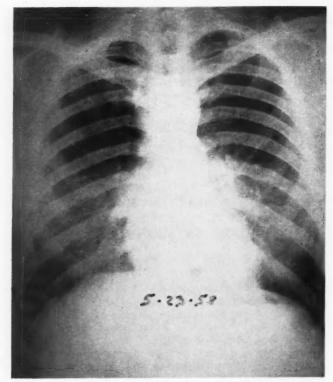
Roentgenogram of the chest, showing ill defined, patchy, mottled densities in the lower lung fields bilaterally.
